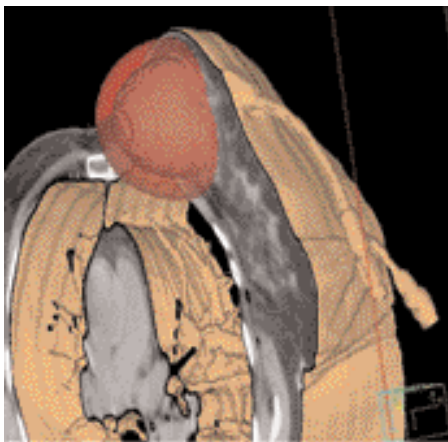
CT after brachytherapy is used to calculate the dose 1.5 to 2 cm beyond the cavity
